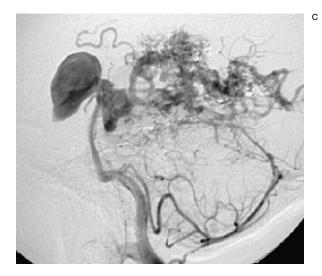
A 42-year-old woman with severe seizures poorly controlled (4-5 seizures per week) on maximal drug therapy. A) MRI shows large incurable AVM. B) Vertebral angiogram shows large occipito-temporal deep AVM and giant basilar aneurysm. C) After 3 embolization sessions nidal flow markedly reduced. Seizure frequency reduced to one in three months.
